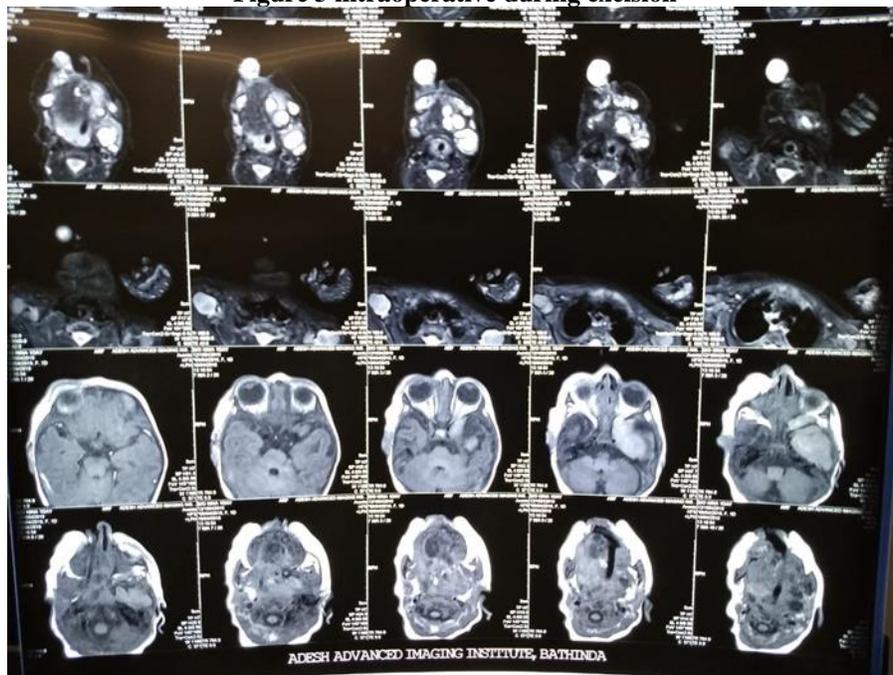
MRI images of teratoma
